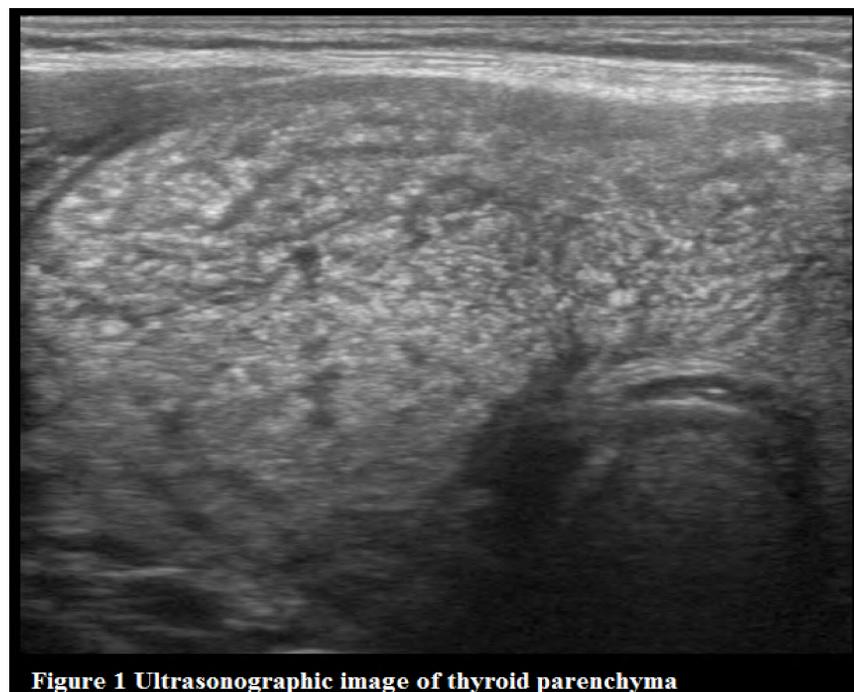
Ultrasonographic image of thyroid parenchyma
